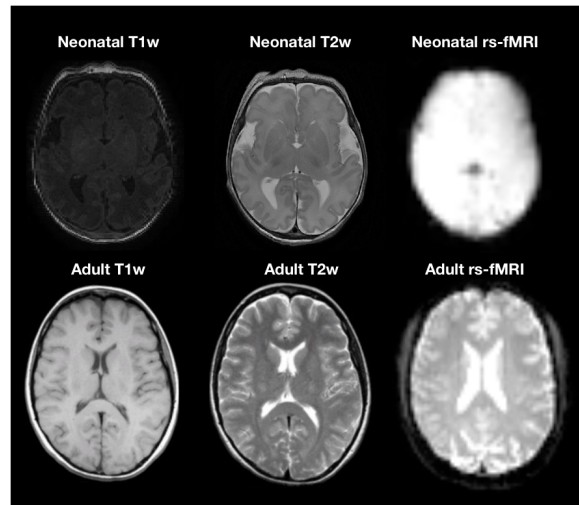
Contrast differences between neonates and adults using MRI.
